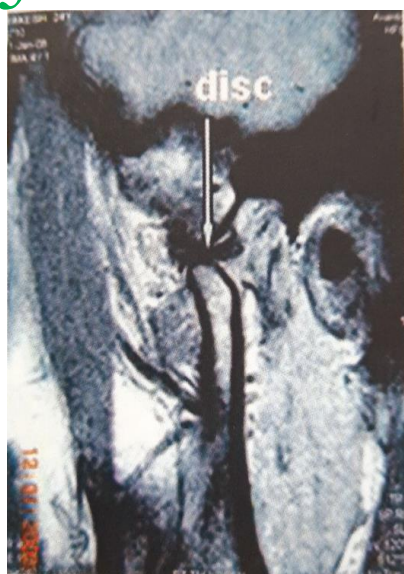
MRI Rt. Open mouth.
